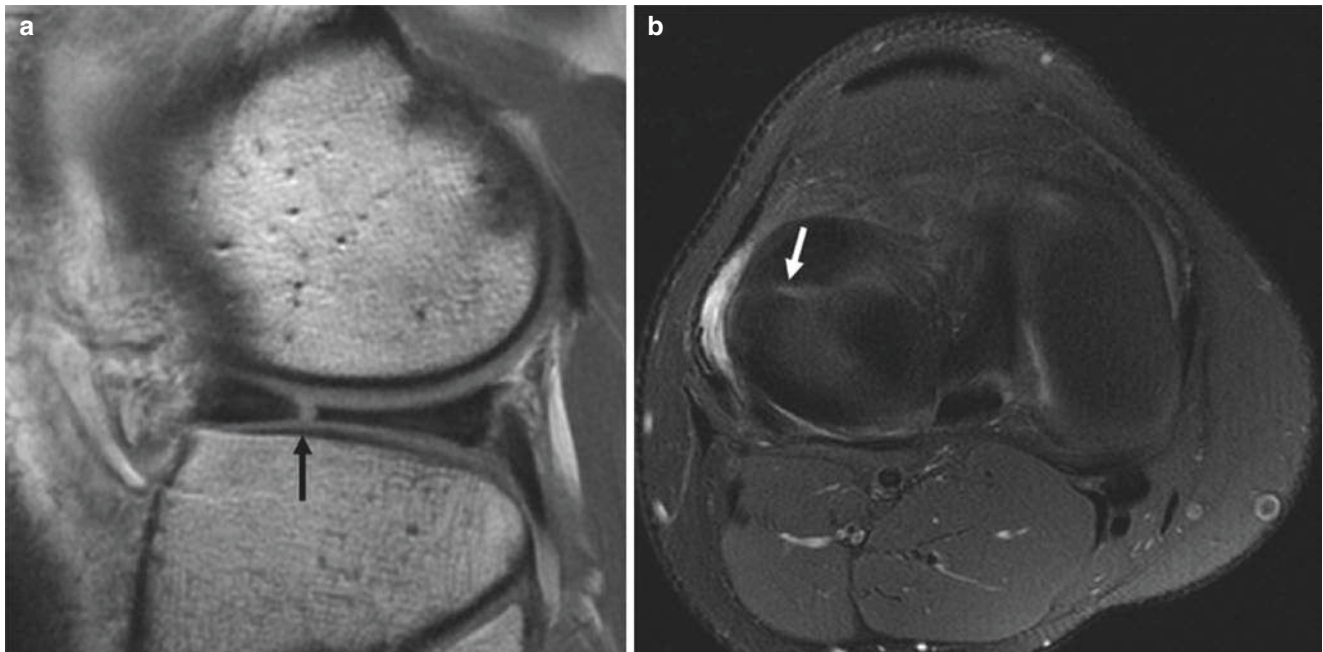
(a) Sagittal proton density MR image demonstrates a radial tear in the body of the lateral meniscus (arrow). (b) The radial tear is seen as a high signal intensity spoke in the wheel of the lateral meniscus on the axial T2 weighted image (arrow)
